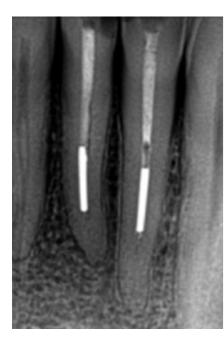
Pre-operative radiograph of two lower incisors with apically placed silver point root fillings
